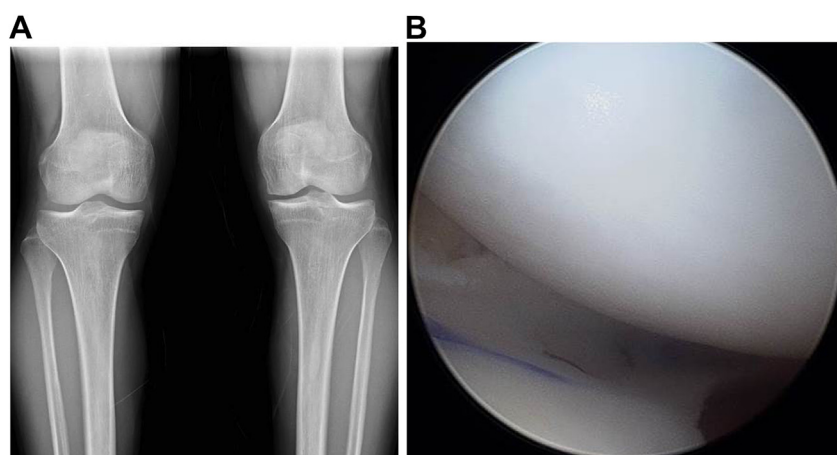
Radiography and arthroscopic image of case 1 obtained 2 years after subtotal meniscectomy of the left knee. (a) Anteroposterior radiograph shows mild narrowing and marginal osteophyte in the medial compartment. (b) Medial meniscus allograft transplantation was performed using the bone plug technique.
